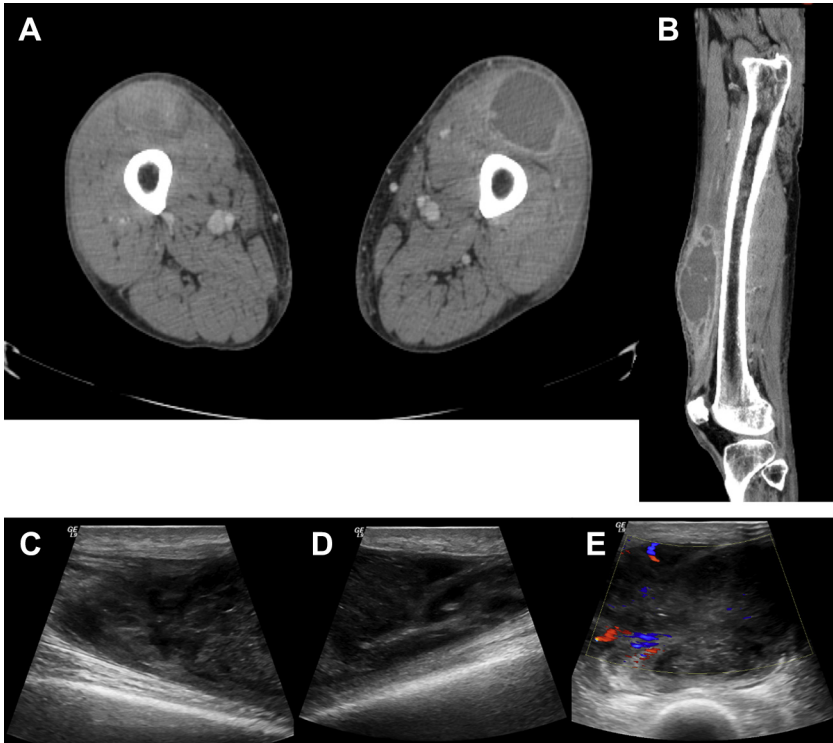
Axial (A) and sagittal (B) contrast-enhanced CT images of an intramuscular abscess in the distal right quadriceps. C and D represent superior (C) and inferior (D) portions of the same area on a split screen gray scale ultrasound image, again demonstrating an intramuscular complex fluid collection anterior to the distal right femur. Note the muscle fibers separated by the fluid collection. (E) Short-axis US image of the same fluid collection, with color flow imaging, demonstrating mild peripheral hyperemia. This correlates with the CT finding of rim enhancement. Although the CT provides exquisite detail of the pathology, the same information is identified with US.
